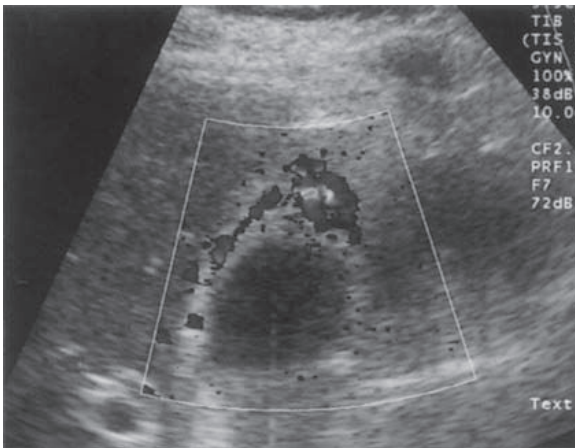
Colour Doppler demonstrates hyperaemia in the thickened gallbladder wall in acute cholecystitis.
